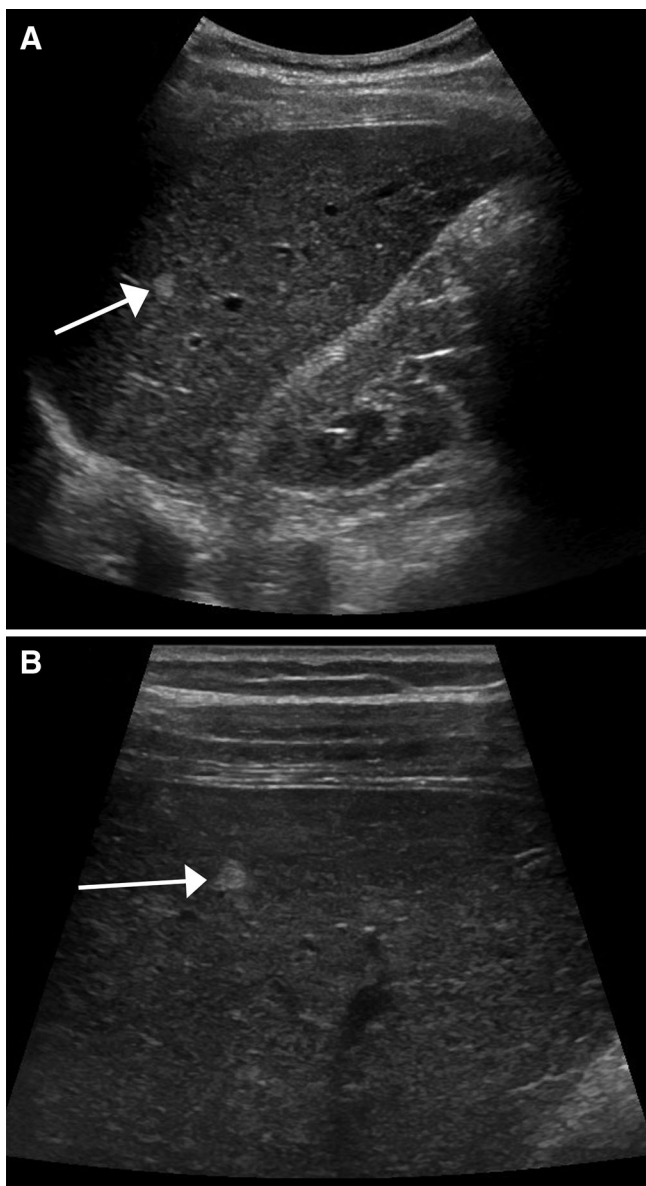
LI-RADS US-2: Subthreshold. A 52-year-old male with chronic hepatitis B. A Grayscale longitudinal image of right lobe of the liver shows focal hyperechoic observation measuring approximately 5 mm (*arrow*). B High-resolution transducer in same location (*arrow*) shows observation to better advantage. Given size of <10 mm, examination is categorized as US-2 subthreshold and recommendation is for follow-up ultrasound at 3–6 months (images reproduced with permission by the ACR).
